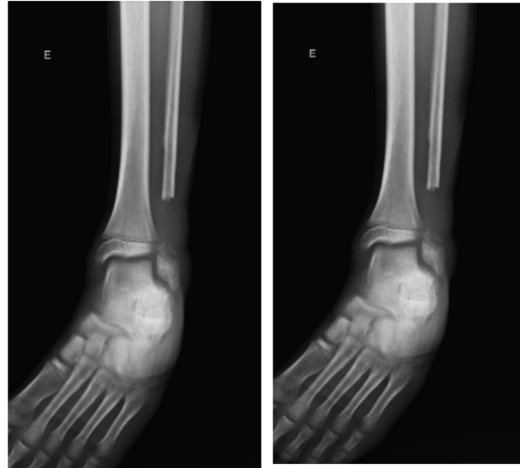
Immediate postoperative X-ray (second surgical procedure) of the left tibio-tarsal joint showing bone defect due to the removal of the necrotic bone fragment.
